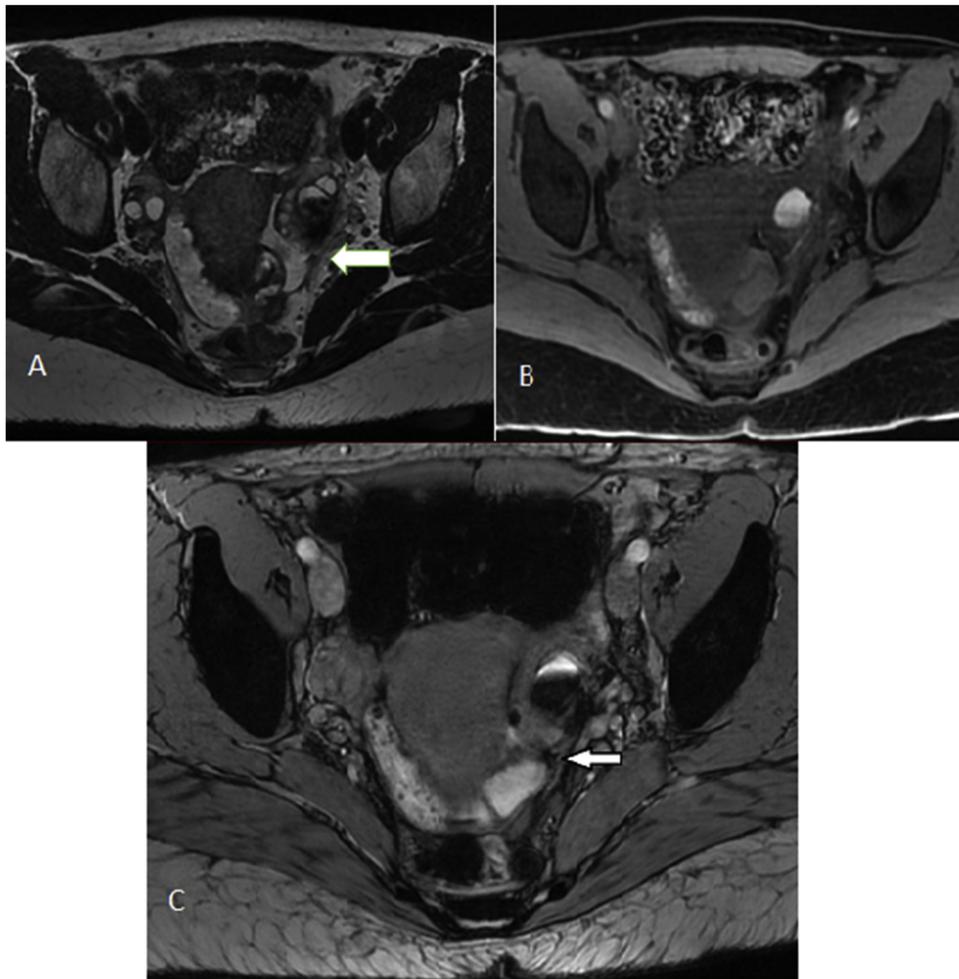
A 35-year-old woman presented with cyclic pelvic pain. A) Axial T2-weighted sequence shows a left cystic mass presenting shading and a no specific thickening of the left USL (arrow). B) Axial fat saturated T1-weighted sequence shows hyperintense cyst defining an endometrioma. There is no hyperintense foci within the left USL. C) Axial SWAN sequence confirms the presence of the endometrioma and reveals the hemorrhagic character of left USL (arrow).
